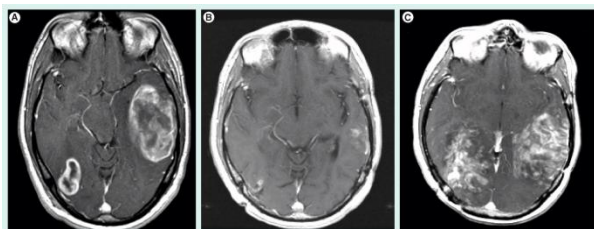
Axial T1-weighted post-contrast magnetic resonance image (MRI) sequences of a patient with glioblastoma. (A) At diagnosis an enhancing multifocal temporal and right parietoccipital tumor is seen. (B) The patient received combined chemo- and radiation-therapy and achieved a response. (C) The tumor recurred 2 years after diagnosis in a diffusely infiltrating fashion and the patient died. (Taken from (9)).
